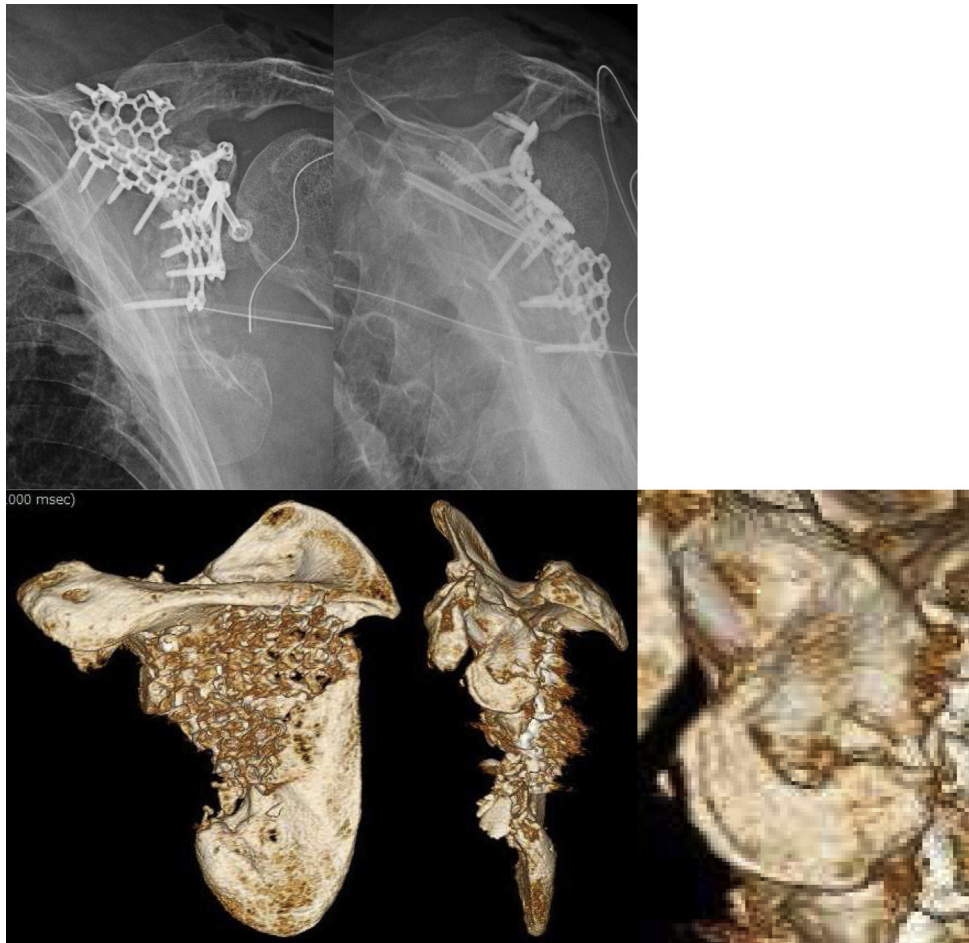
X-ray and CT after the second reconstruction surgery showing good reduction of the glenoid fossa with two CCSs and mesh plates. CT, computed tomography; CCSs, cannulated cancellous screws.
